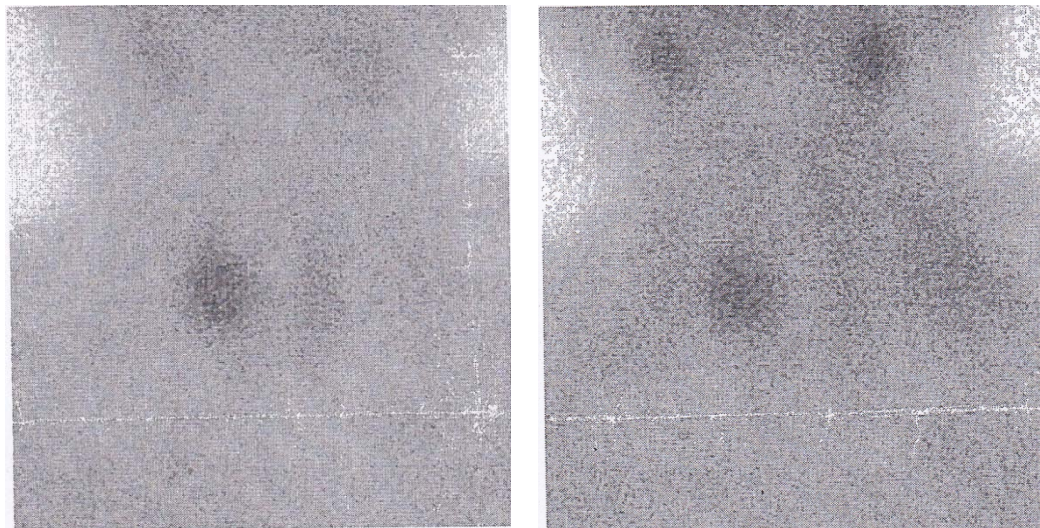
Static scintigraphy with radiopharmaceutical, ^{99m}Tc -MIBI: the finding corresponded to scintigraphic presentation of hyperplasia or hyperfunctional adenoma of the right inferior and superior parathyroid glands.
